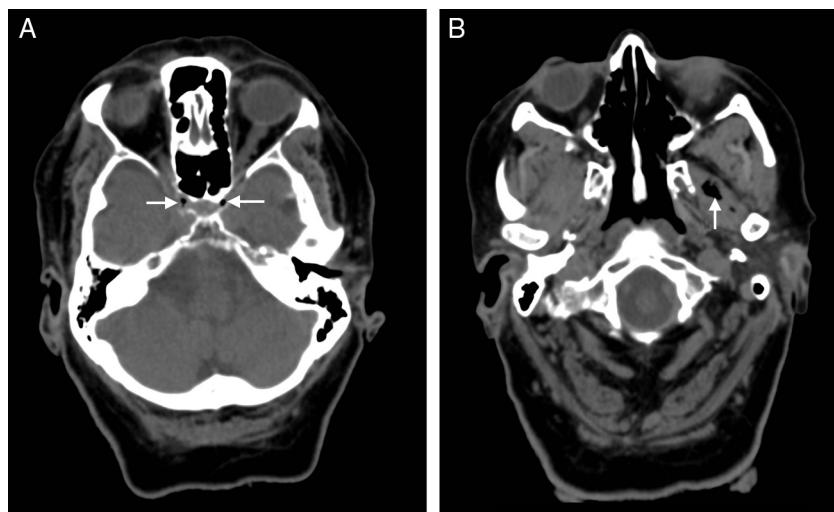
A simple axial CT scan performed 50 minutes after symptom onset revealed air bubbles (arrow heads) inside both cavernous sinuses in the parasellar region (A) and at the level of the left lateral pterygoid muscle (B), adjacent to the trajectory of both internal carotid arteries, which exhibit signs of intracavernous atheromatous calcification.
